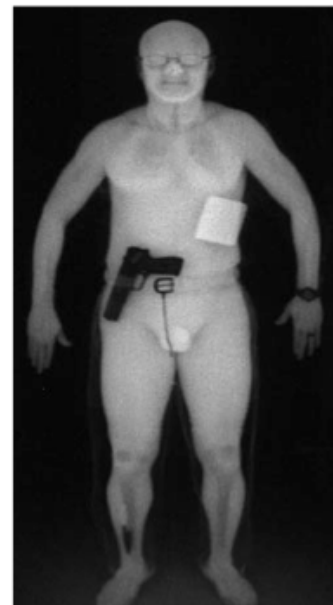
Image formed on detector on the same side as x-ray source:
